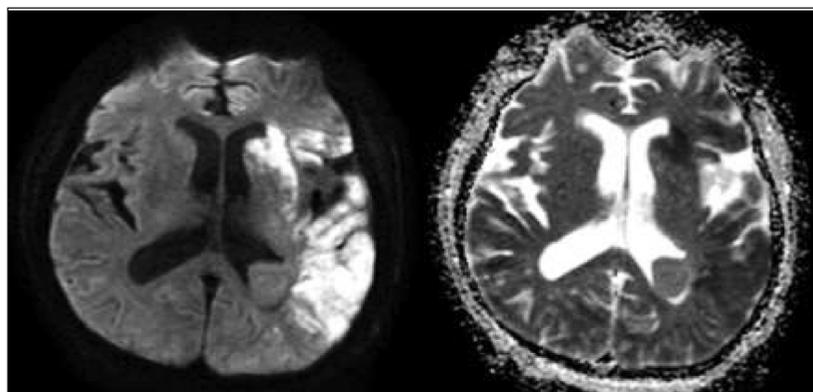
Diffusion weighted magnetic resonance imaging, taken due to the persistence of focal neurological deficit, showing acute middle cerebral artery infarction.
